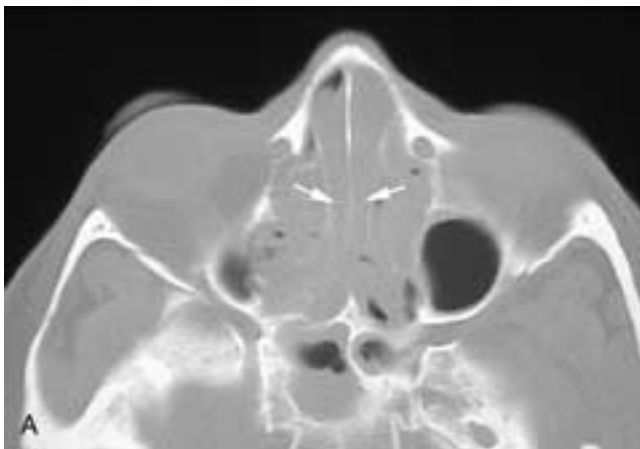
Axial (A) and coronal (B) CT scans show soft-tissue disease opacifying the ethmoid sinuses and inflammatory mucosal thickening in the sphenoid and maxillary sinuses. Polypoid soft tissues also fill both nasal fossae. Note that the normally thin olfactory recesses of the upper nasal fossae are widened (*arrows*). This suggests that the nasal masses are chronic nasal polyps.
